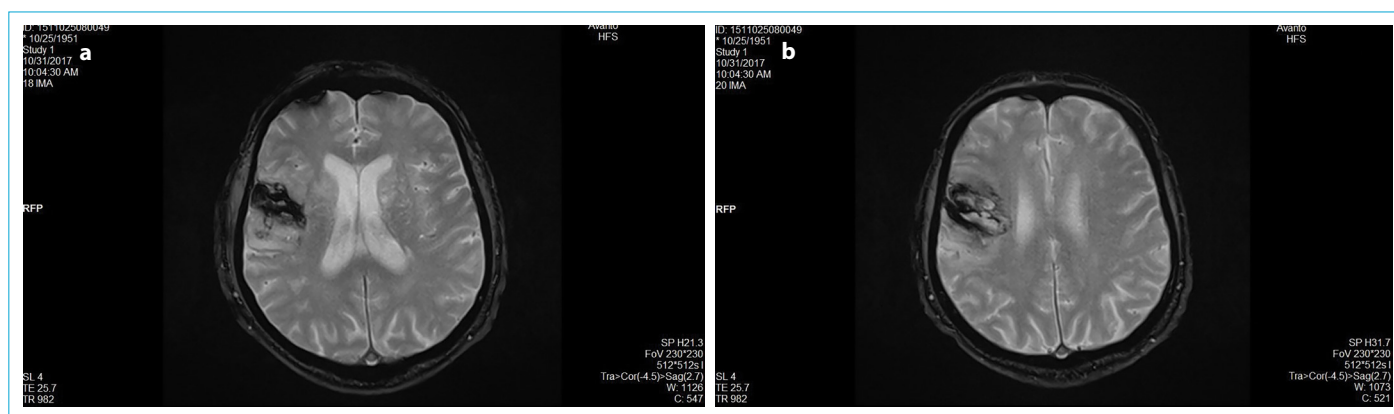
(a, b) MRI for Patient A done at 3 months after ischemic stroke with hemorrhagic transformation, 10 weeks after treatment of ischemic stroke on the right medial cerebral artery; at this time-point patient had recovered over 90% of motor function on left side, less fine motor skills (buttoning/unbuttoning shirt).
